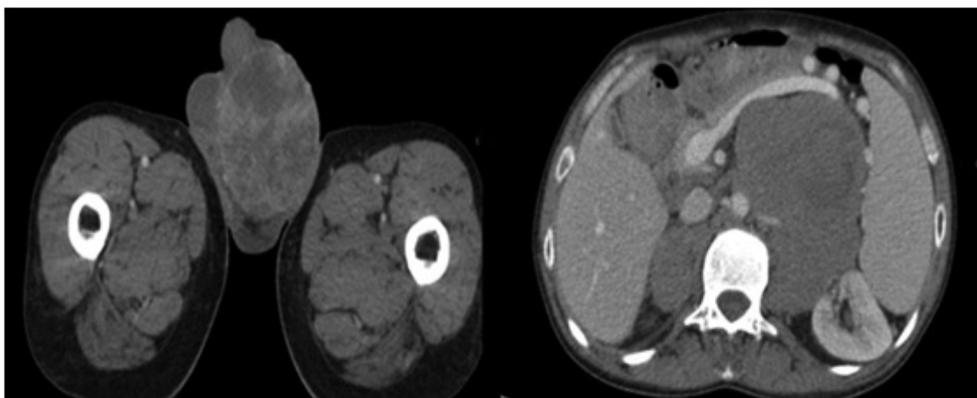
Computed tomography, which evidences tumor in the left testicle and voluminous retroperitoneal mass in the left that pushes away the adjacent structures
